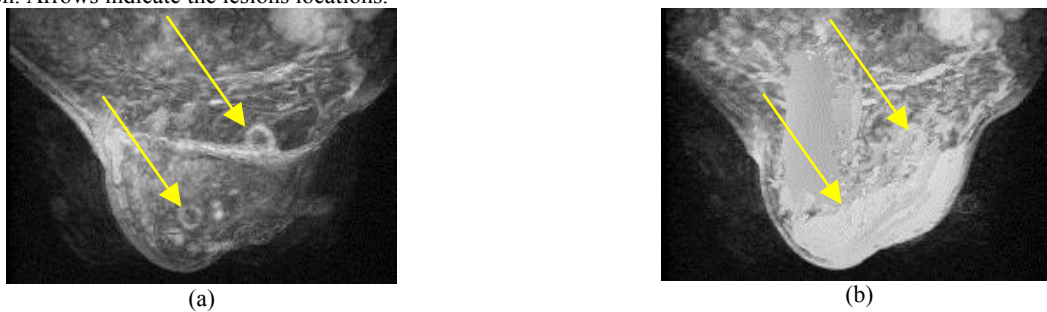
Maximum intensity projections (MIP) of MRI differential dynamic image series (preGd-Gd1) of the left breast using GRE sequence: (a) MIP at 190° after SSHT FEM, (b) MIP at 190° before SSHT FEM.
